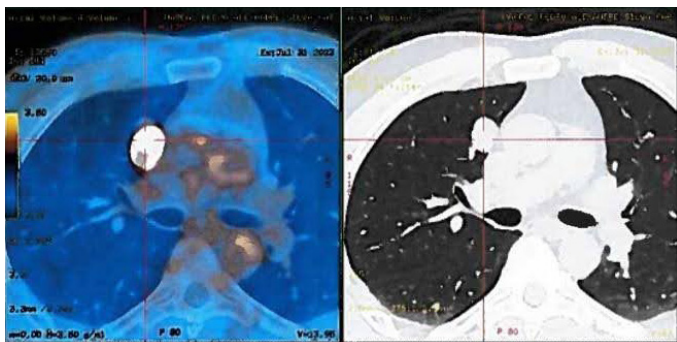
PET/CT showing a hypermetabolic nodular formation in the right upper lobe.
